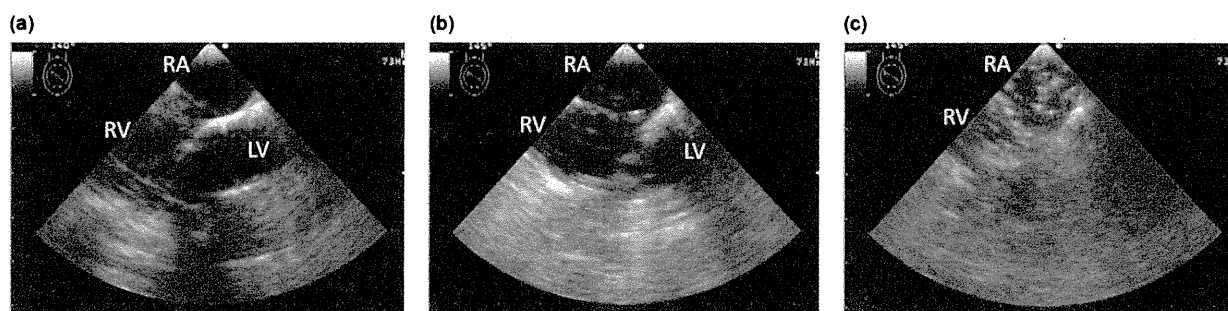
Examples of definitions of gas embolism (GE) Grade 0 (a), Grade 1 (b), Grade 2 (c). (a) The right outflow tract of the heart (ROT) is visualized by transesophageal echocardiography (TEE); (b) An arrow indicates a gas bubble seen as a white round spot; (c) An arrow indicates a compact mass of gas bubbles filling ROT. LV left ventricle, RA right atrium, RV right ventricle
